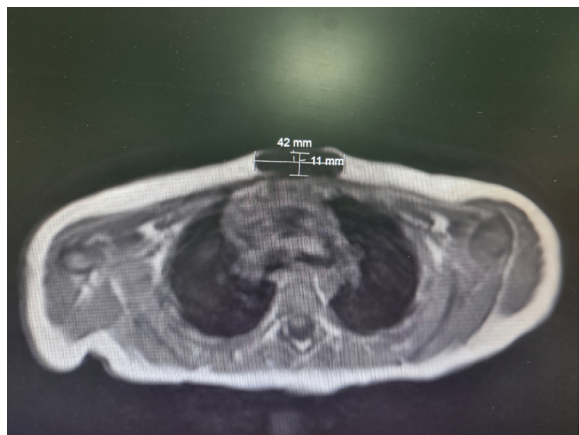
MRI image of lymphangioma in Case 2.
